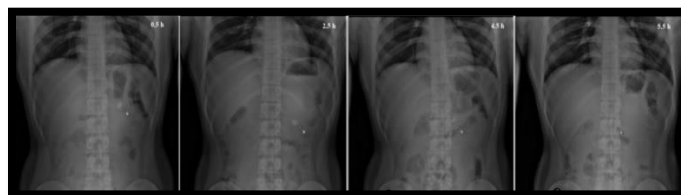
Radiographic images showing the presence of BaSO₄-loaded sustained release effervescent floating bilayer tablets of nateglinide in the stomach of volunteer-C at different time points (the location of the tablet is shown with an arrow).
